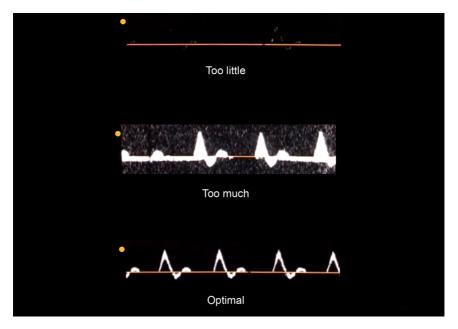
When adjusting the Doppler gain, too much will cause the waveforms to disappear; too little will cause background distortion.
